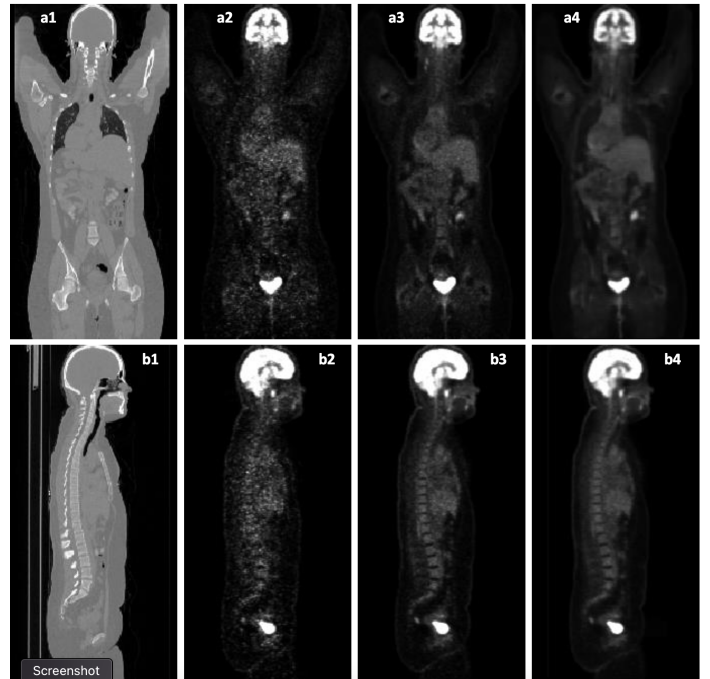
Visual results. (a1-a4) shows the sagittal views of CT, low count PET, full count PET and synthetic full count PET images. (b1-b4) shows the coronal views [Lei et al. \[2020b\]](#).
